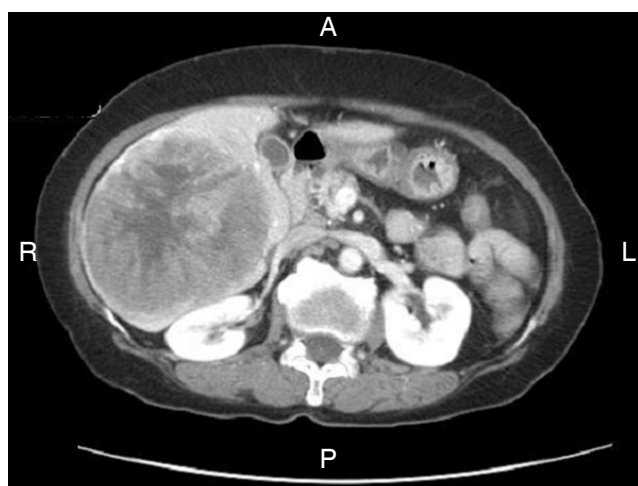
Contrast enhanced computed tomography image of the abdomen demonstrates a large enhancing tumor right hepatic lobe consistent with biopsy proven hepatocellular carcinoma
